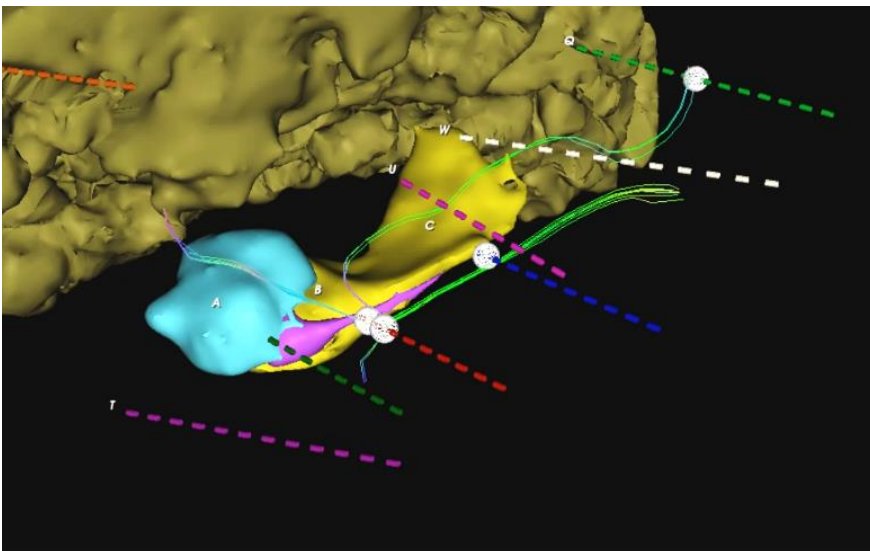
SEEG-Electrome: Four electrical regions defined by electric contacts *I* bipolar configuration connected via DWI tracts. White spheres are located at the intersection of two consecutive contacts. Tractography was computed with the Dextroscope®.
